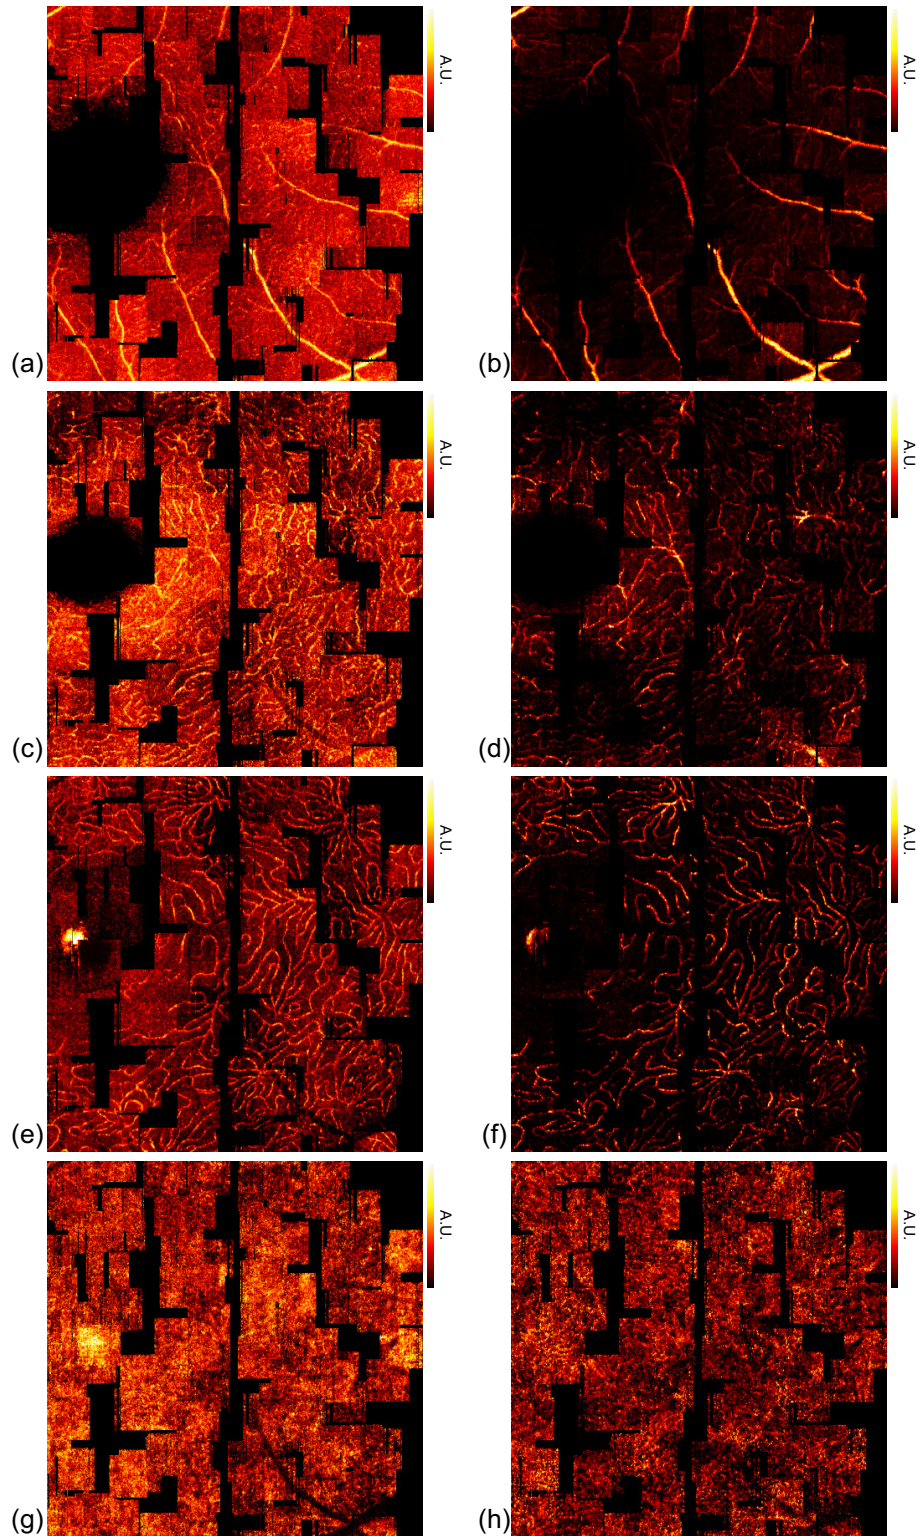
Wide-field *en face* projections of intensity (left column) and Doppler power (right column) images at different depths of the GCL and IPL ((a) and (b)), IPL/INL boundary ((c) and (d)), INL/OPL boundary ((e) and (f)) and choriocapillaris ((g) and (h)).
